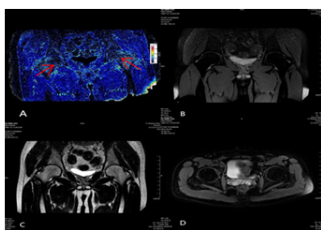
Reduced R2* in bilateral femoral heads without abnormal MRI findings Fig. 3: Reduced R2* in bilateral femoral heads with abnormal MRI findings.
